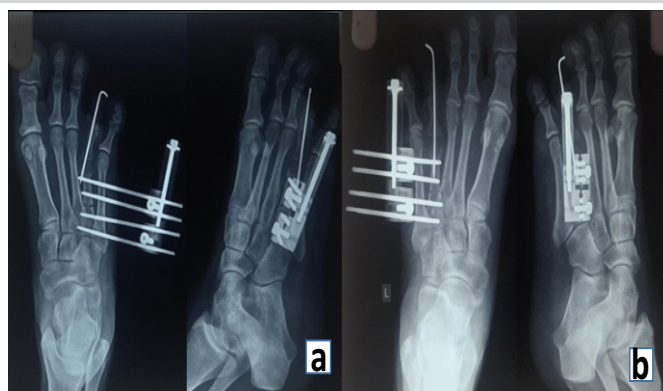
Immediate post-operative X-ray. (a) Left foot anterior posterior view and oblique view. (b) Right foot Anterior posterior view and oblique view.
